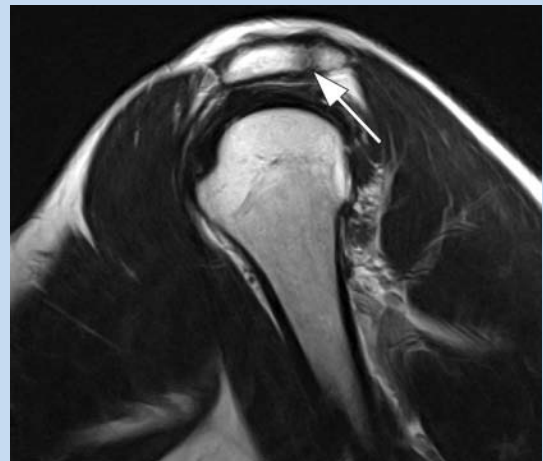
The persistent apophysis (arrow) is visible anterior to the posterior aspect of the acromion on the T2-weighted sagittal oblique image.
